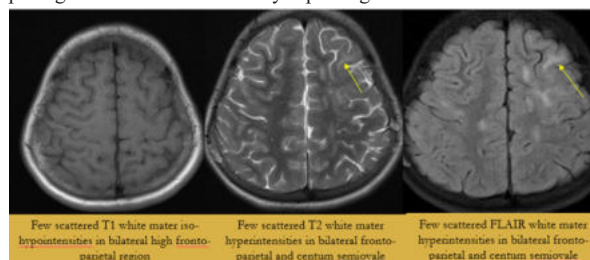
showing T1 iso-hypo, T2 & FLAIR hyperintensities.
